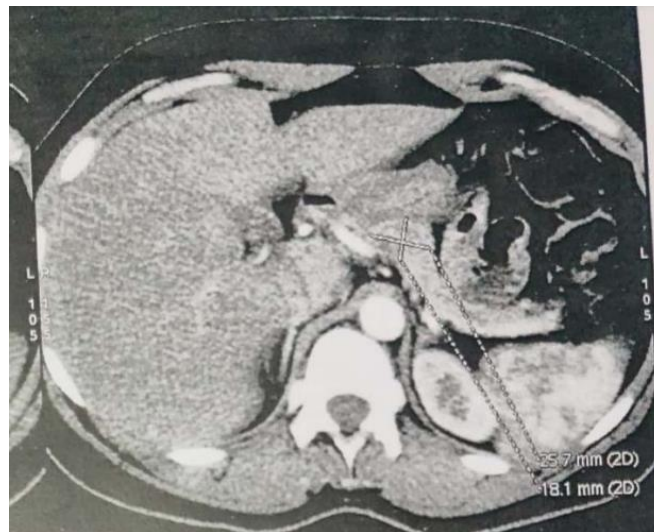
Imaging from a CT scan showing a tumor of the pancreatic isthmus measuring 18 mm
